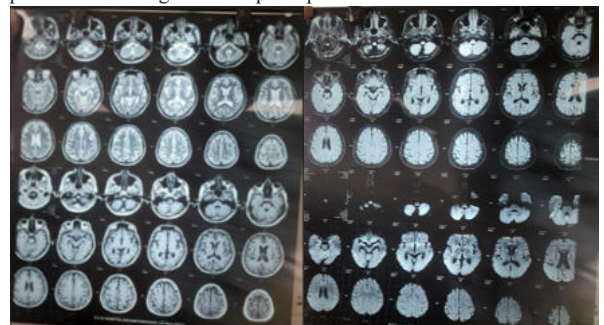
MRI brain showing T2 Flair hyperintensities in medial aspect of bilateral thalami and peri aqueductal grey matter showing mild restriction on DWI and no reversal on ADC, Prominent ventricular system and sulcal spaces with mild cerebral atrophy
